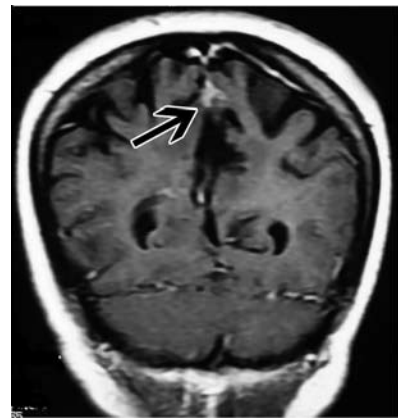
Mass lesion appears to be totally resected in the control T1W MR images.
